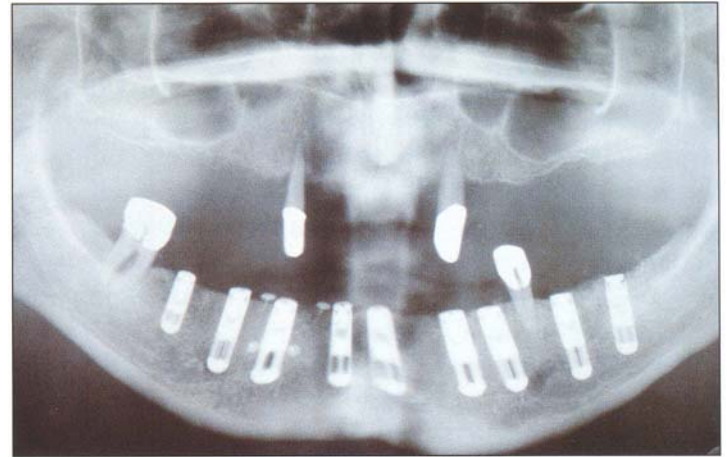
7a Panoramic radiograph of a 49-year-old patient. The atrophic posterior maxilla presented with less than 4 to 5 mm vertical residual bone height. Hence, delayed implant placement is required.
